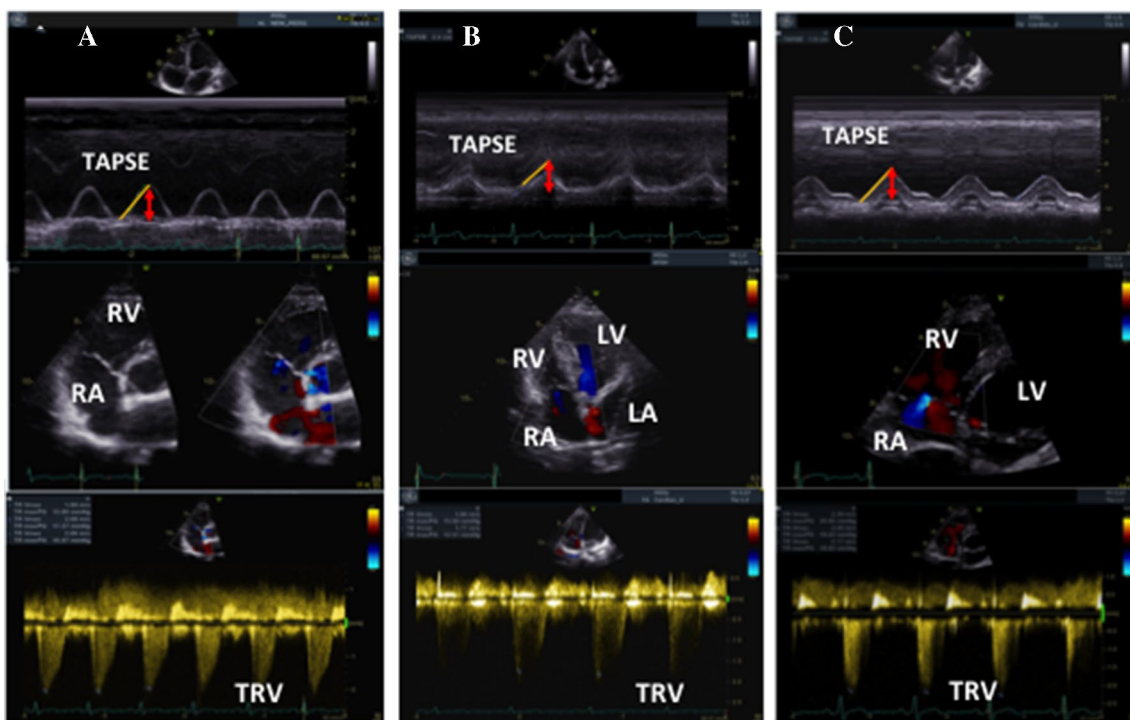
Apical 4-chamber view and M-mode cursor placement at the tricuspid lateral annulus (top). Color signal of TR (middle). Maximal velocity by continuous wave (CW) Doppler signal of TRV from
